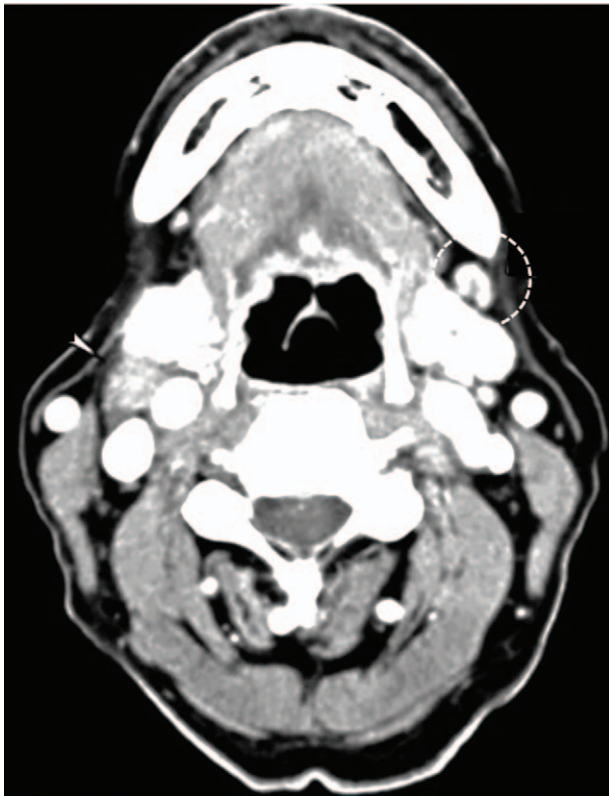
The representative figure of neck computed tomography scanning of 62years old man. A white circle indicates enlarged (>1 cm in the transverse plane) cervical lymph node.
